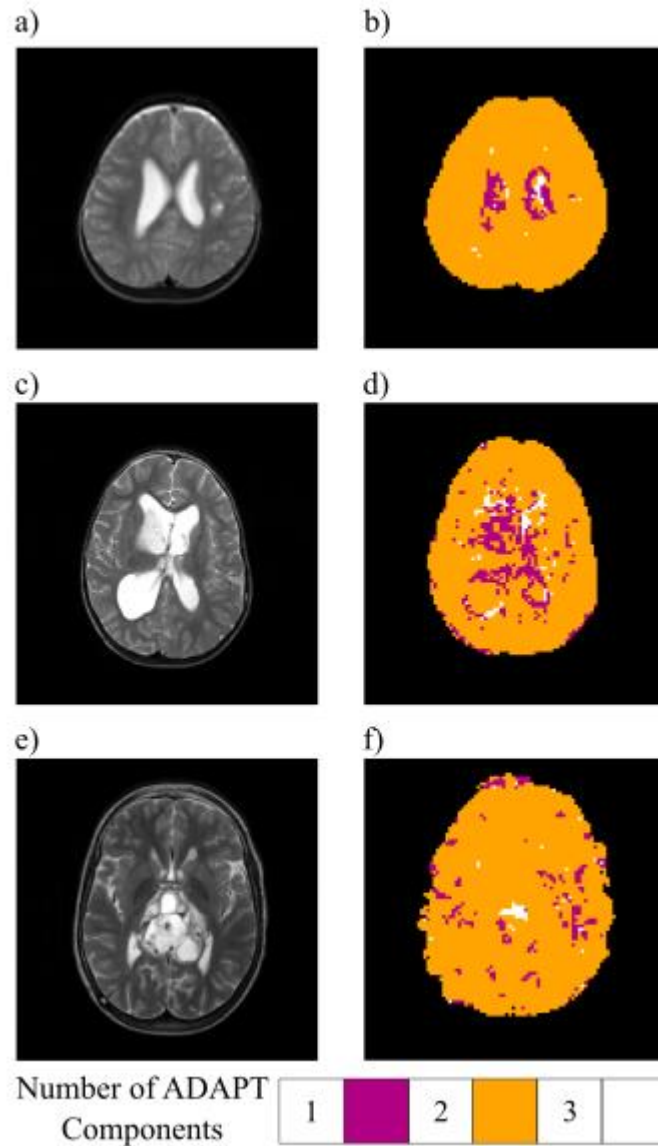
Example case of the ADAPT method applied to In-Vivo DWI axial slices. a) Axial b0 image, enlarged ventricles, b) ADAPT component map. c) Axial b0 image, enlarged ventricles and low perfused tumour, d) ADAPT component map, e) Axial b0 image, high perfused tumour, f) ADAPT component map.
